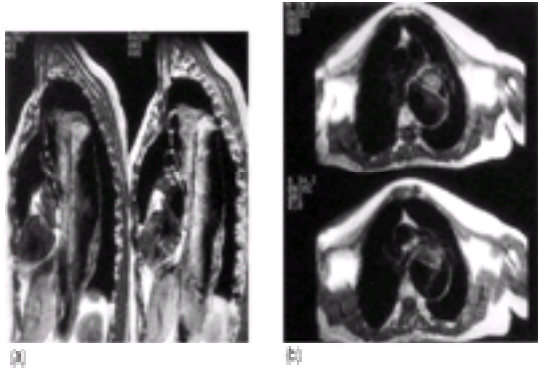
(a) Longitudinal and (b) transverse MRI of chronic, aneurysmal type B dissection.
